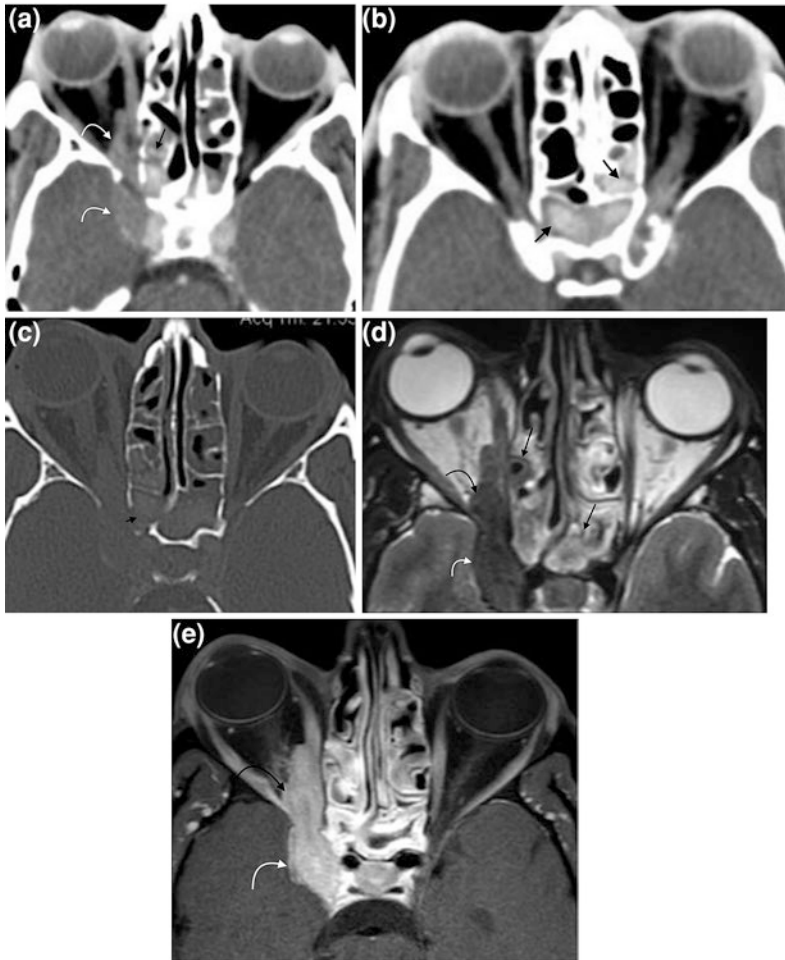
Intraorbital and intracranial spread of invasive fungal sinusitis. a–c axial non-contrast CT images soft tissue window and bone window and d–e axial T2WI and axial post contrast T1WI demonstrate soft tissue opacification of the PNS with high attenuation content which appears of low signal on T2WI (arrows). Associated osseous defect at the lateral wall of the sphenoid sinus is noted (arrow head). There is an adjacent right orbital enhancing soft tissue that extends intracranially through the right optic canal to the right parasellar region (curved arrows). Note that the osseous defect is better demarcated on CT images, whereas the intracranial extension is better depicted in MR
